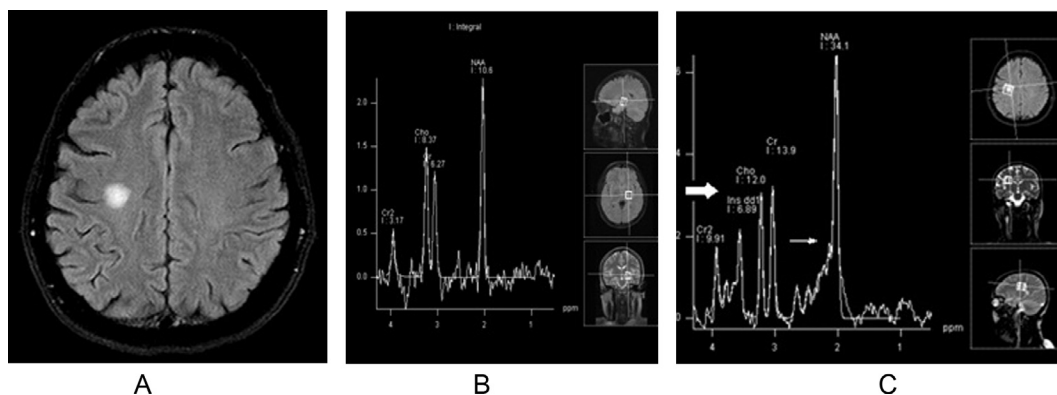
Female patient 36 years old with chronic MS (A) Axial MRI brain T2 FLAIR images showed right parietal hyperintense lesion, (B) and (C) MRS at long and short TR showed: Reduced glutamate (thin white arrow), mild raised level of myoinositol (thick white arrow), and reduced NAA/Cr ratio.
